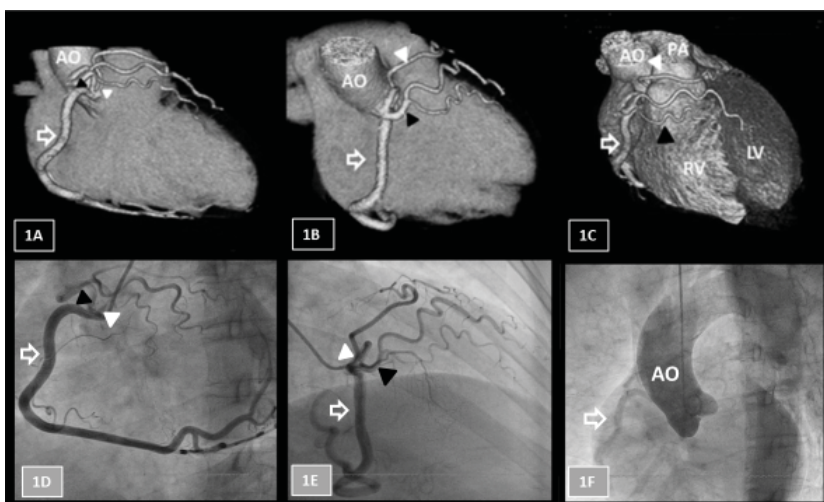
Comparison between CT coronary angiogram and invasive coronary angiogram in the left anterior oblique (1A and 1D), right anterior oblique (1B and 1E), and straight anterior posterior (1C and 1F) views. Hollow white arrow: right coronary artery; Black triangle: anomalous obtuse marginal artery; White triangle: first diagonal branch to the lateral LV wall that continued to supply the apex; AO: aortic root; PA: pulmonary artery; LV: left ventricle, RV: right ventricle. No left anterior descending artery (LAD) was visualised in the inter-ventricular groove (1C). Aortogram highlighting the aortic root (AO) showed absence of both LAD and left circumflex artery from the left coronary cusp (1F).
